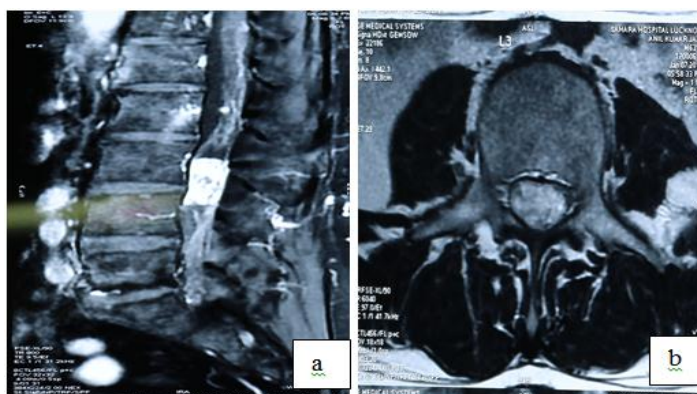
(a) and (b): MRI of the Lumbosacral Spine- T1 with contrast sequence shows an intradural extramedullary lesion at the level of L3-L4 occupying the entire spinal canal.
